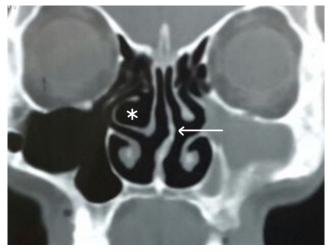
Coronal CT showing right sided concha bullosa (star) and left sided nasal septal deviation (arrow)
